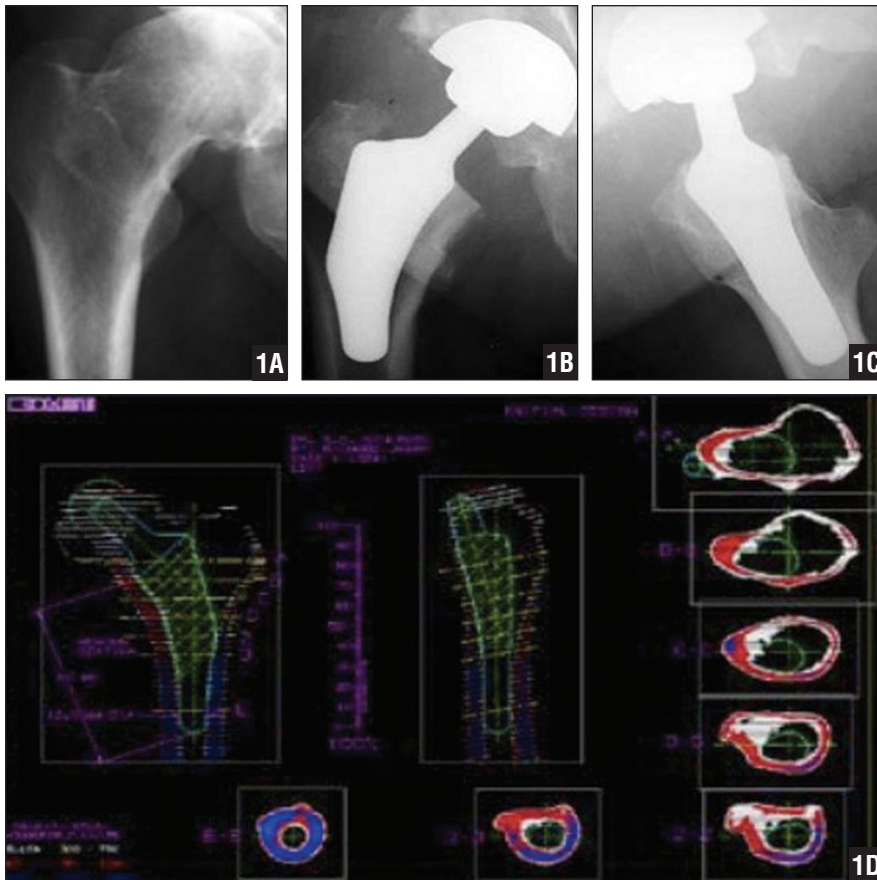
Preoperative anteroposterior (A) and postoperative anteroposterior (B) and lateral (C) radiographs showing the right hip that underwent THA with a computed tomography–based, short-stem implant. Three-dimensional analysis and sizing was used to produce an implant with optimal fit and fill in the metaphysis (D).
